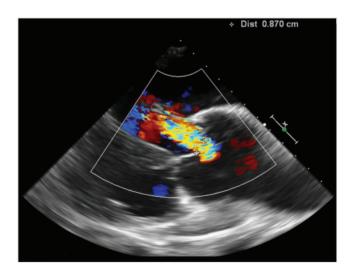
Preoperative Doppler echocardiography demonstrates aortic root aneurysm and associated severe aortic insufficiency.
